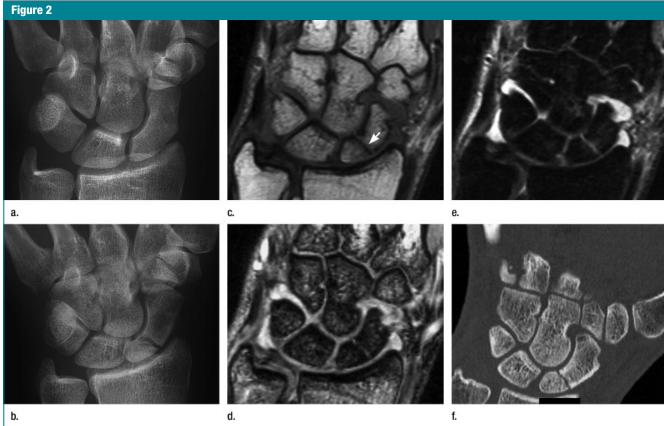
Complete scaphoid fracture in a 25-year-old man. (a) Initial conventional radiograph is negative; (b) after 6 weeks, a clear fracture line could be seen. Coronal (c) T1-weighted (500/20), (d) T2-weighted three-dimensional gradient-echo (60/17, 20° flip angle), and (e) STIR (1200/13/130) MR images obtained 4 days after trauma demonstrate complete cortical and trabecular fracture line in the scaphoid bone that is hypointense on c (arrow) and hyperintense on d and e. (f) Coronal multiplanar reformation from multidetector CT performed on the same day shows nondisplaced fracture of the scaphoid.
